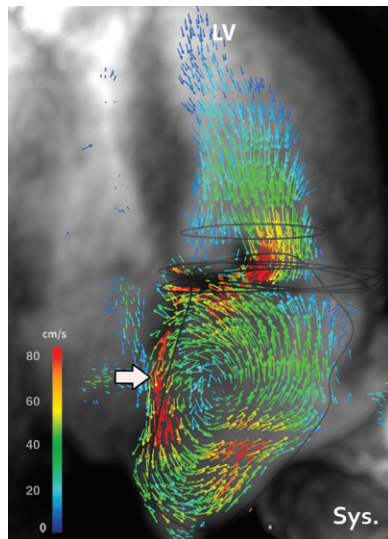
Severe complex mitral regurgitation in a 52-year-old woman. Cardiac 4D flow MRI was performed to better assess mitral regurgitation that was difficult to characterize with transthoracic echocardiography. Image with velocity vectors shows the course of a high-velocity eccentric jet (arrow). Note the marked vortical flows in the dilated left atrium during systole (*Sys*). LV = left ventricle.
